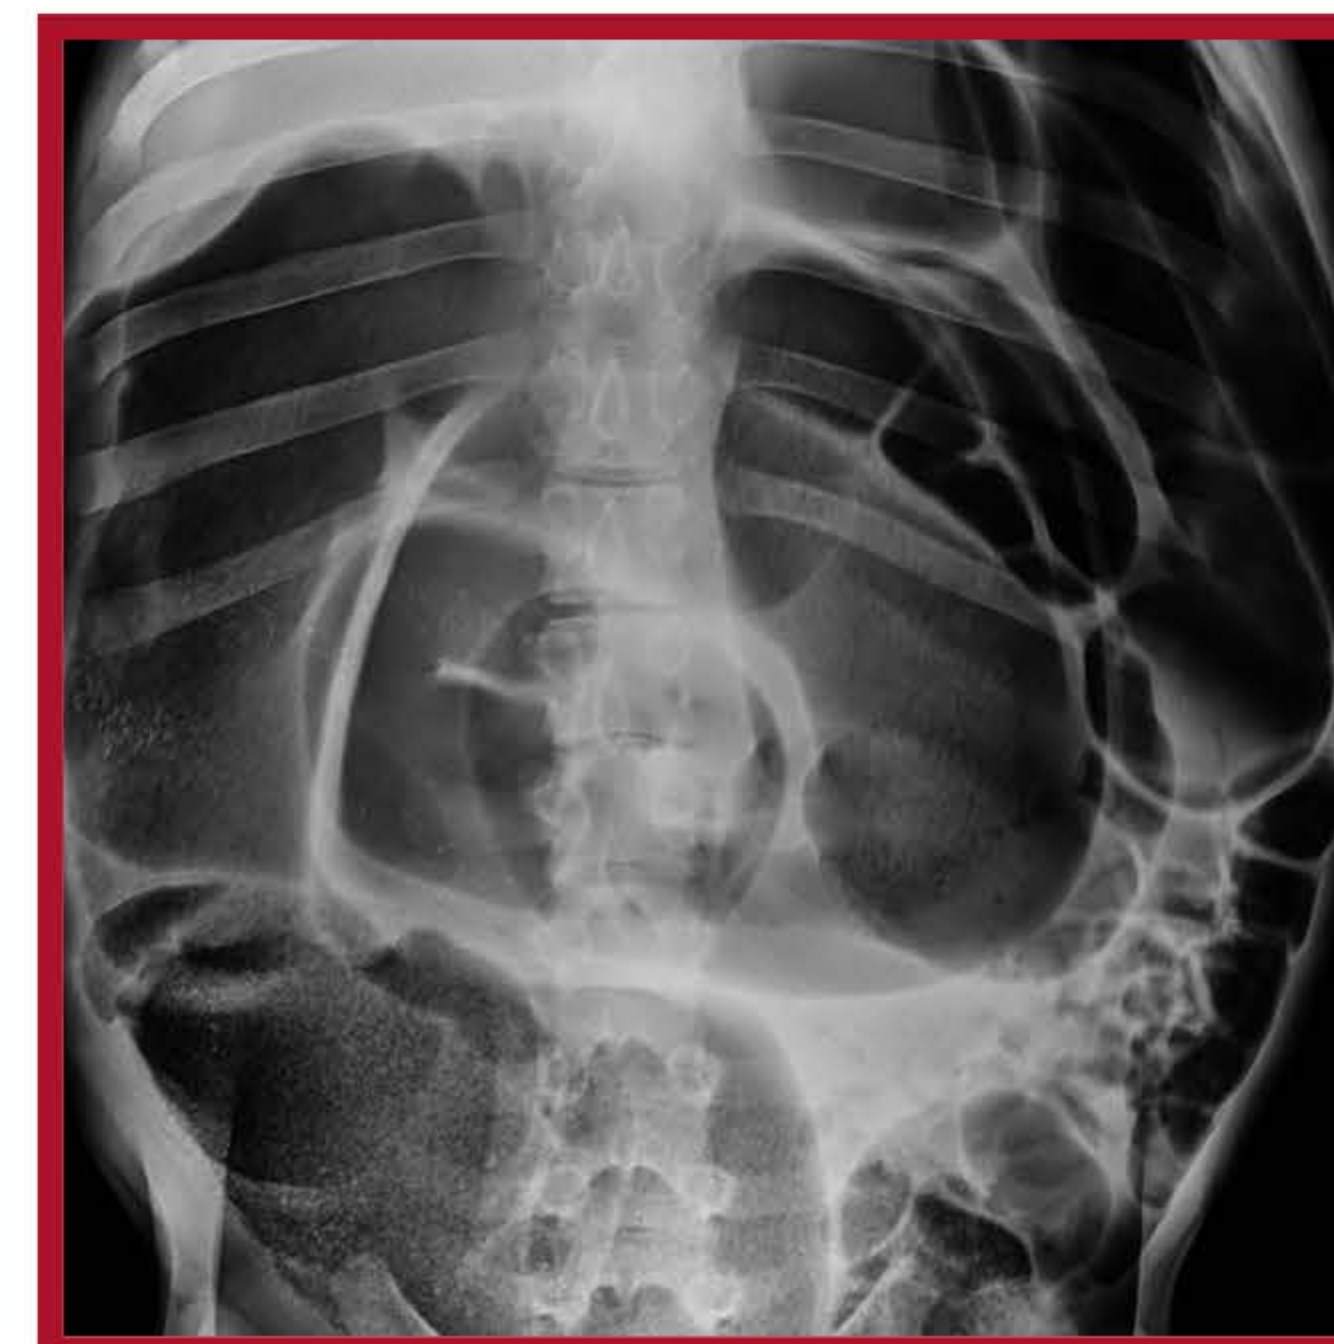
Ventrodorsal (VD) abdominal radiograph
